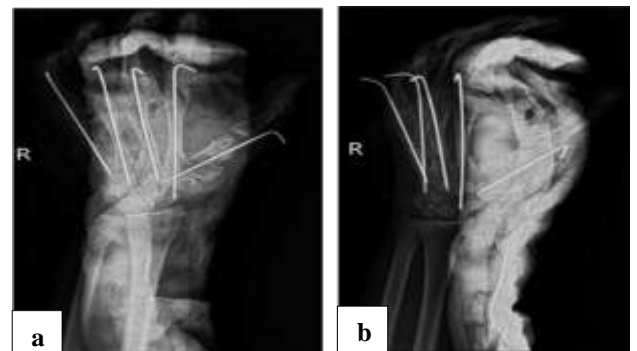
(a and b): Initial X-ray of the patients' hand.
